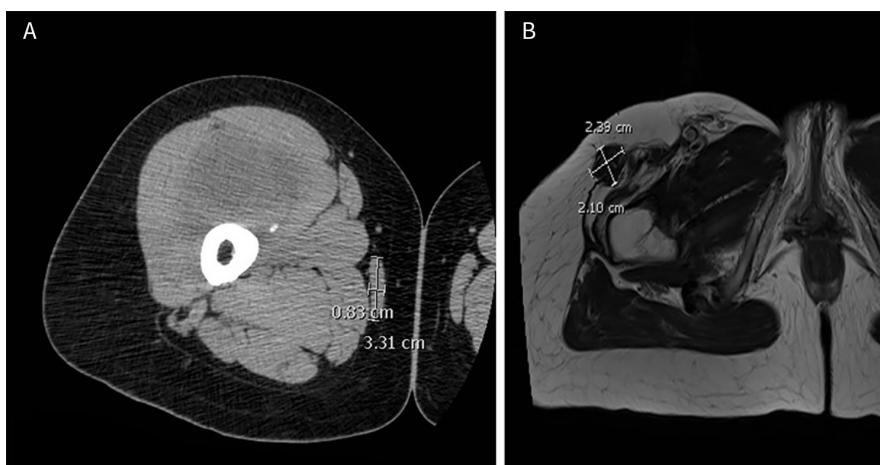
MRI showing right gracilis muscle hypertrophy post functional muscle transfer: (A) pre-operative MRI; and (B) 12-month post-operative MRI. MRI: magnetic resonance imaging
